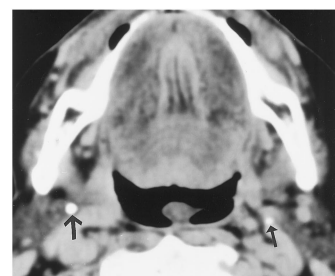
Eagle syndrome. Axial CT image (soft tissue algorithm) shows an enlarged and densely calcified right styloid process (*large arrow*). The left stylohyoid ligament is normal (*small arrow*). The patient's symptoms resolved after surgical removal of the right styloid process.
